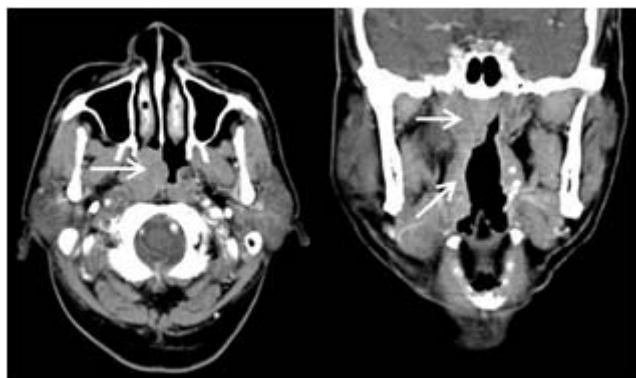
NHL of Waldeyer’s ring. Axial enhanced CT scan showed mass at right side of nasopharyngeal wall and oropharyngeal wall (arrow), extending to posterior right nasal cavity. Pathology was diffuse large B-cell lymphoma.
